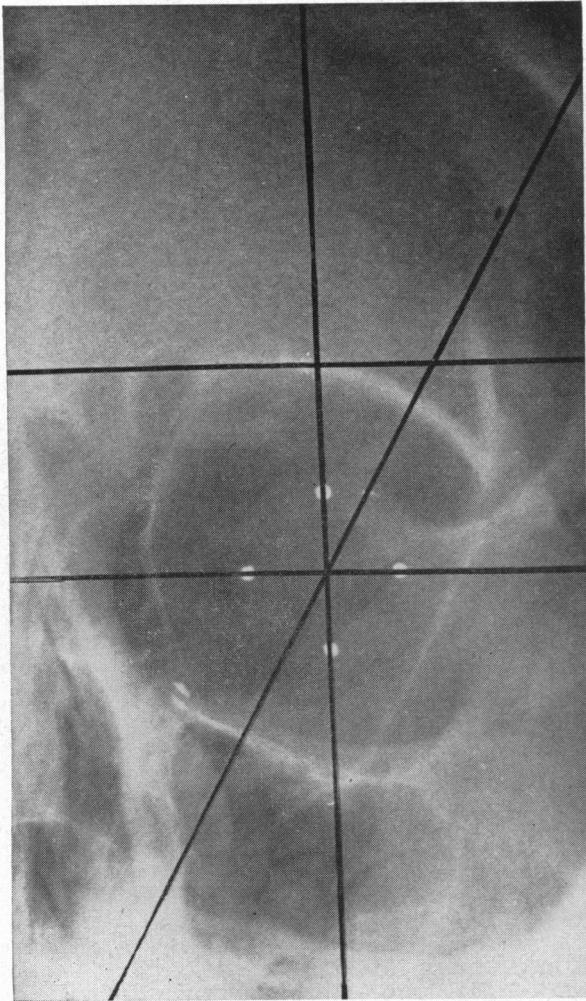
Roentgenogram with lines for localization of foreign body in frontal plane according to Comberg.
